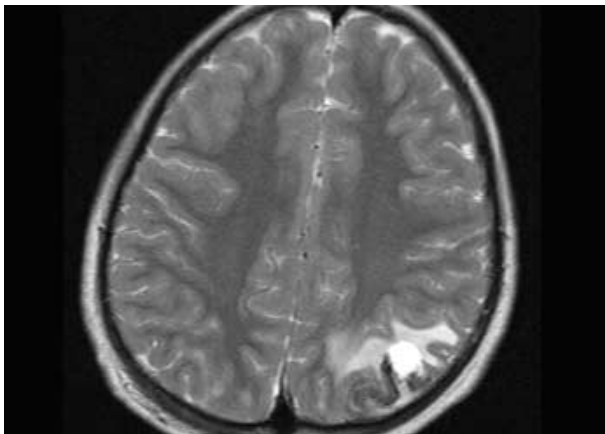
MRI reveals that the lesion shows irregular peripheral rim enhancement pattern, focal meningeal enhancement adjacent to the mass and surrounding edema.
